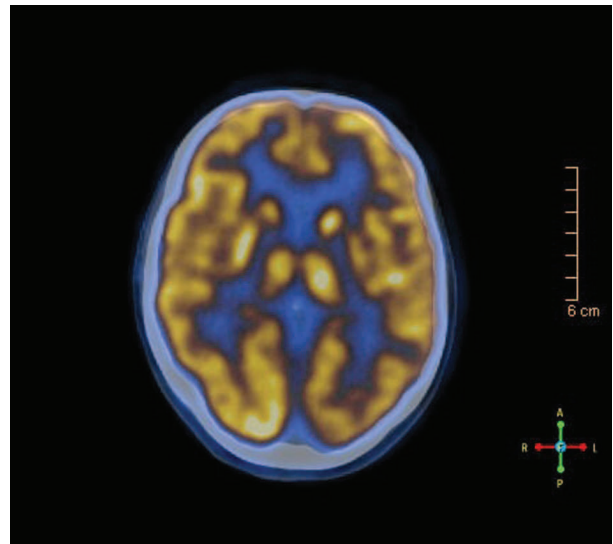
Normal FDG-PET/CT
